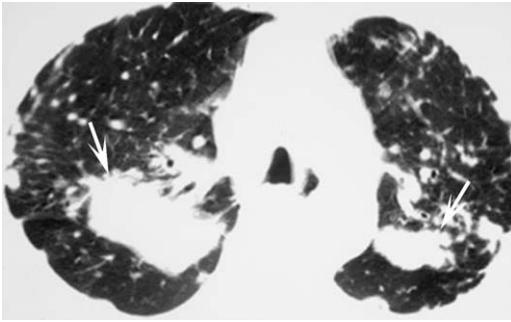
HRCT assessment of emphysema: irregular air space enlargement (previously referred to as “cicatrical emphysema”). Axial HRCT image through the upper lobes in a patient with complicated silicosis shows opacities consistent with progressive massive fibrosis (*arrows*), associated with irregular low attenuation in the wake of the upper lobe opacities; the low-attenuation areas represent irregular air space enlargement.
